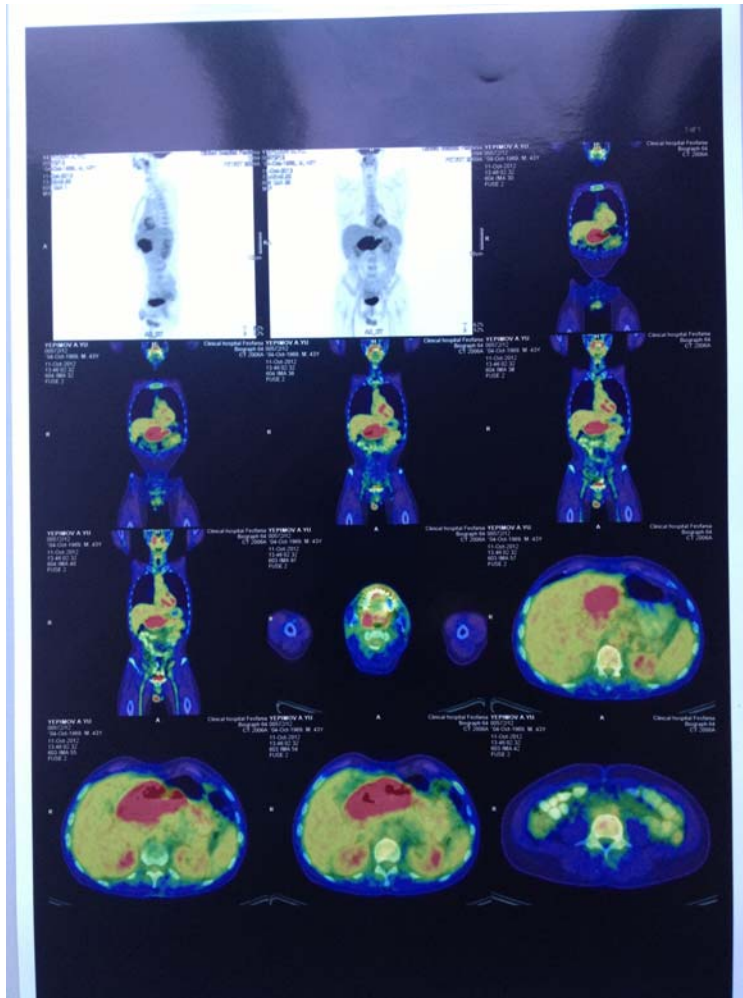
The results of PET / CT in the diagnosis of gastric lymphoma in a patient A
